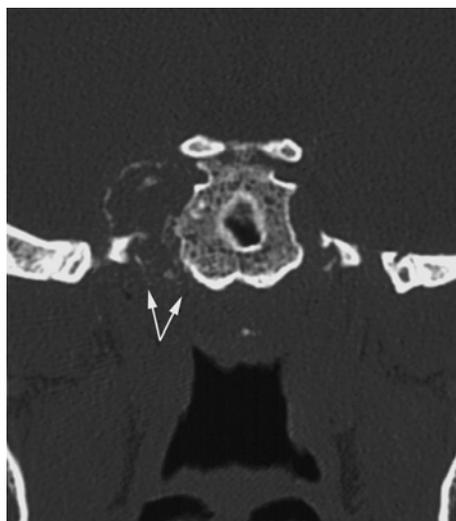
Chondrosarcoma of the right petro-clival suture. Unenhanced CT in the coronal plane shows small, thin calcifications lining the boundary of the mass that extends submucosal through the foramen lacerum into the nasopharynx (arrows)
